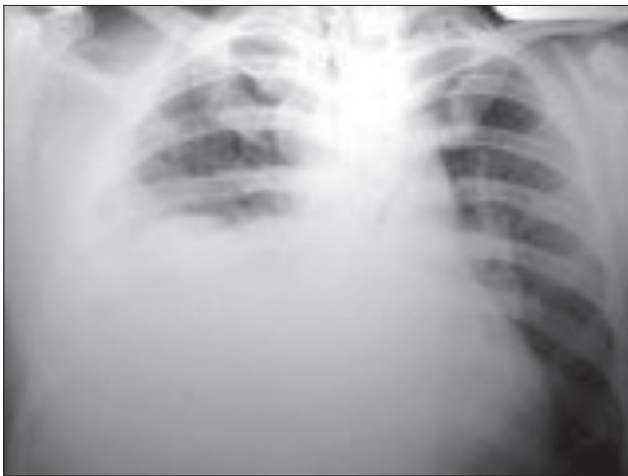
Chest radiograph showing gross elevation of the right hemidiaphragm.
